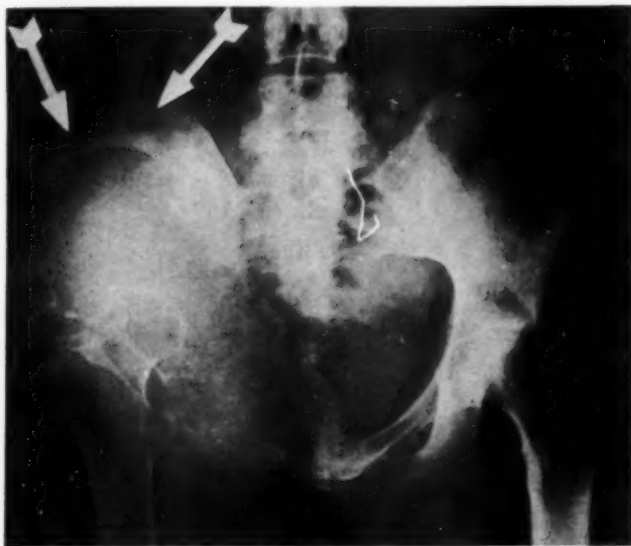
Roentgenogram of the pelvis, Oct. 22, 1941, showing destructive changes in all the right pelvic bones. Note the two small punched out areas of destruction in the upper remaining rim of the innominate (arrows). Definite soft-tissue involvement is present. Beginning destruction of the left pubic bone at the symphysis is also present.
